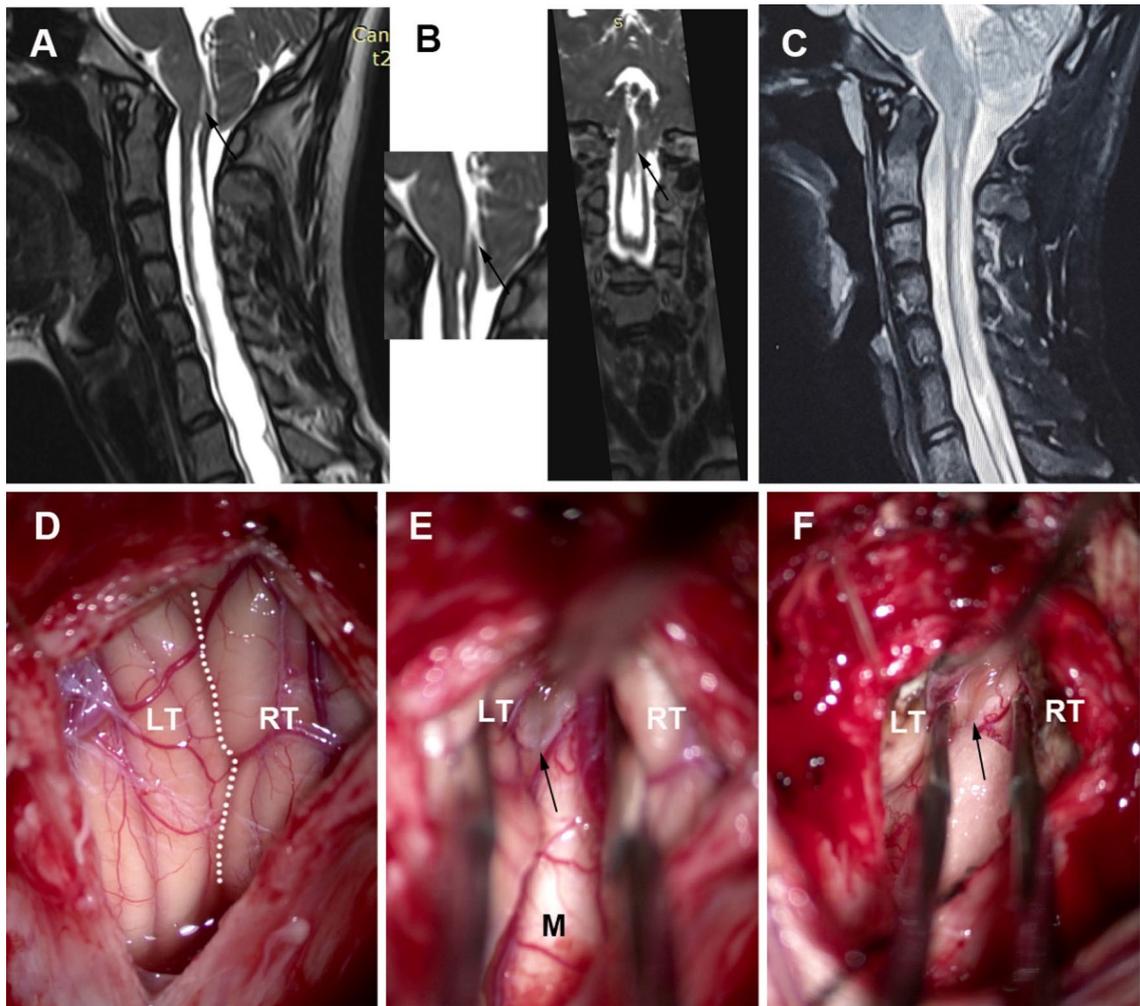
Partial communicating SM case. a Preoperative midsagittal T2-weighted MR image of CVJ. Note the SM extend upwards to the medulla oblongata without dilated fourth ventricle. b High resolution MR showed a detectable channel between the fourth ventricle and the SM (black arrow) on a certain level. c Postoperative MRI showed
